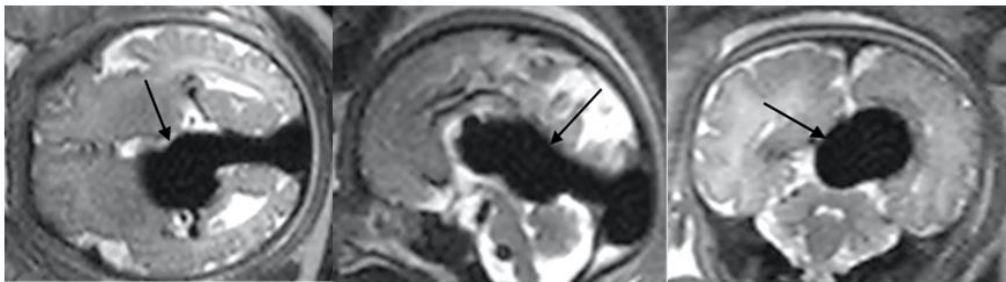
A-C: Multiplanar T2-weighted images at 28 weeks of gestation show a well-defined, markedly T2 hypointense, oval-shaped mass measuring 35x31mm along the midline, corresponding to an aneurysmal dilatation of the vein of Galen (Arrows).
